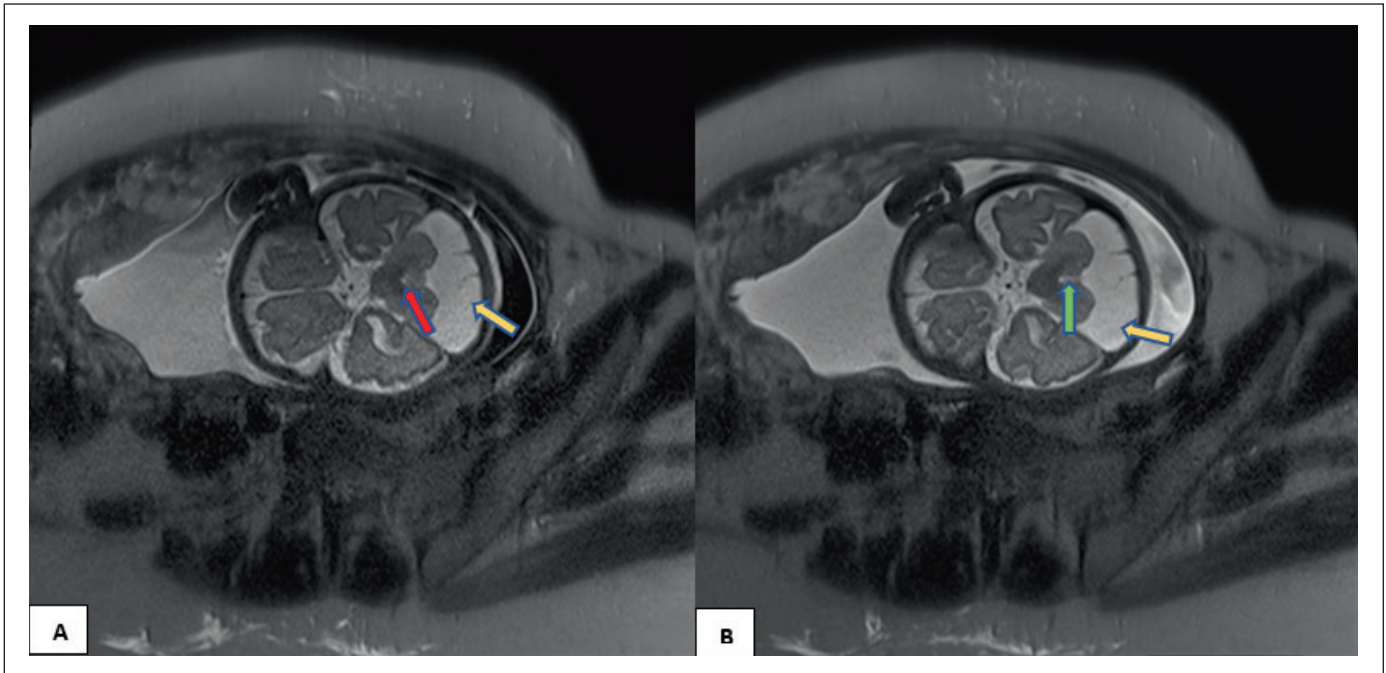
A T2-weighted fetal MRI (axial sections) presents (A) presence of superior vermis (pink arrow), and (B) absent inferior vermis (green arrow) with a large posterior fossa cyst (yellow arrows).
